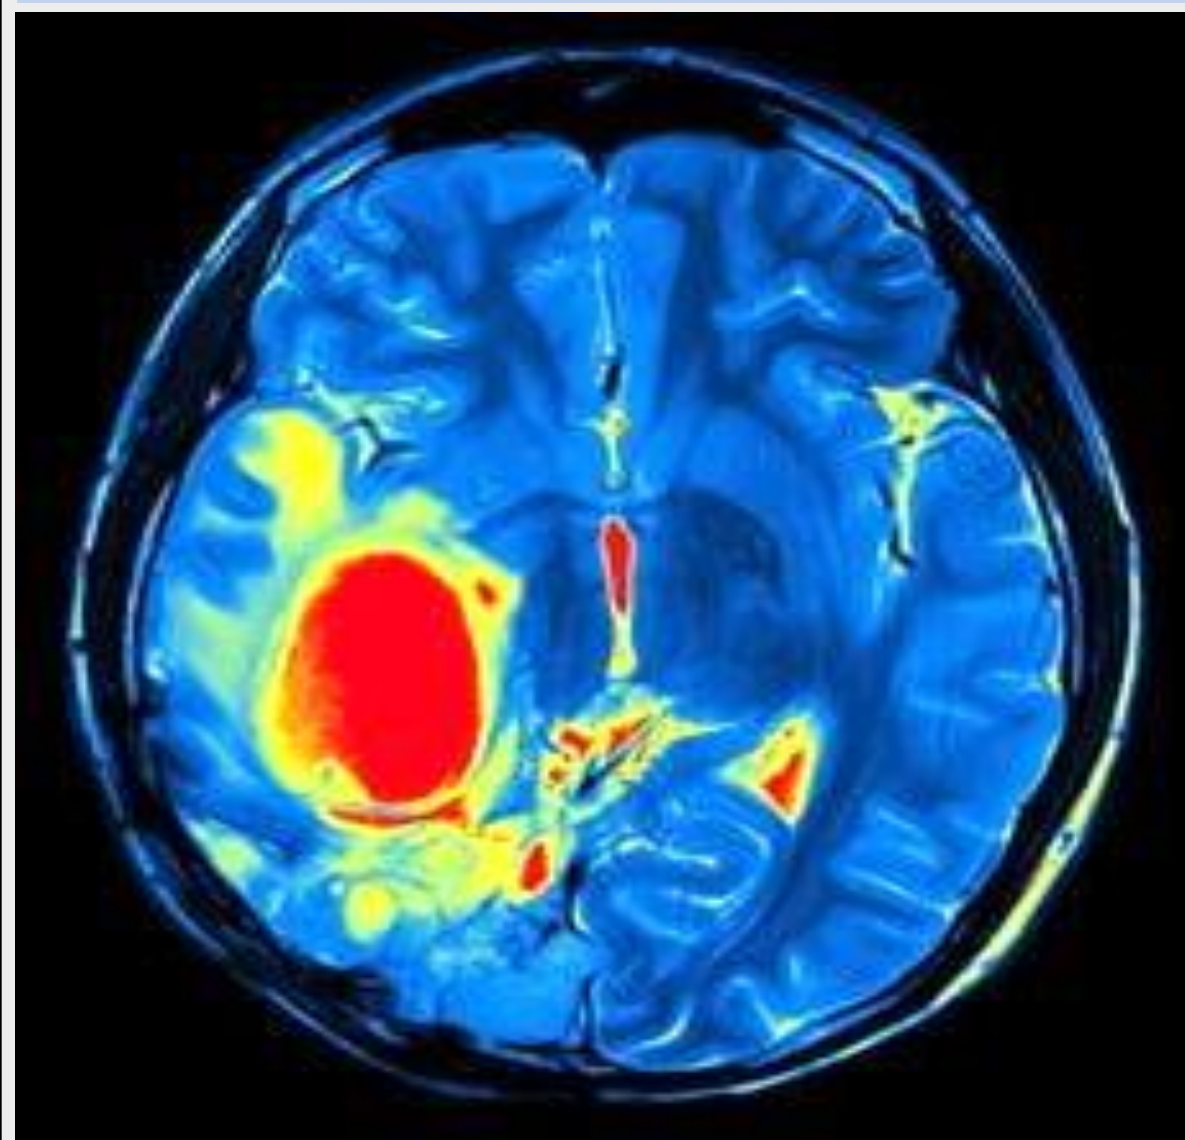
MRI shows a GBM tumor located in the posterior left temporal lobe.
